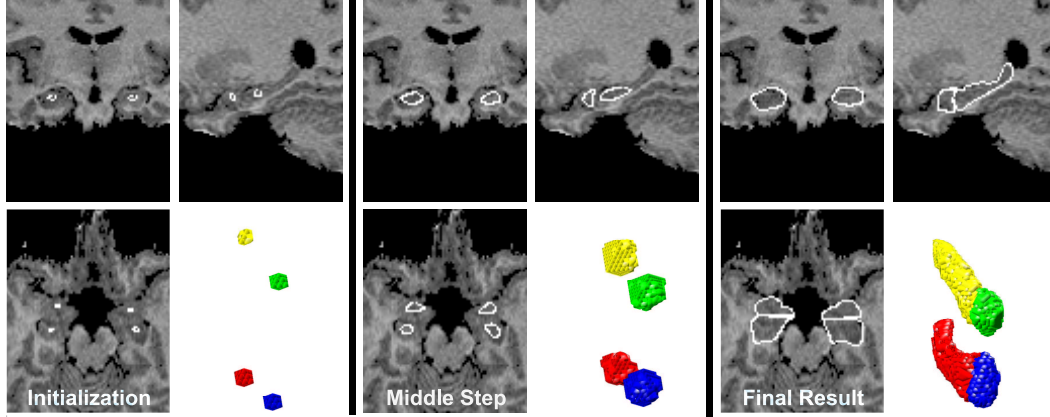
Stages in the simultaneous segmentation of both the left and right amygdalae and hippocampi from a T1-weighted 3D MR brain image. Included with permission. $\lambda_k = 0.1$, $\omega_k = 0.9$, $k = 1, 2, 3, 4$.
